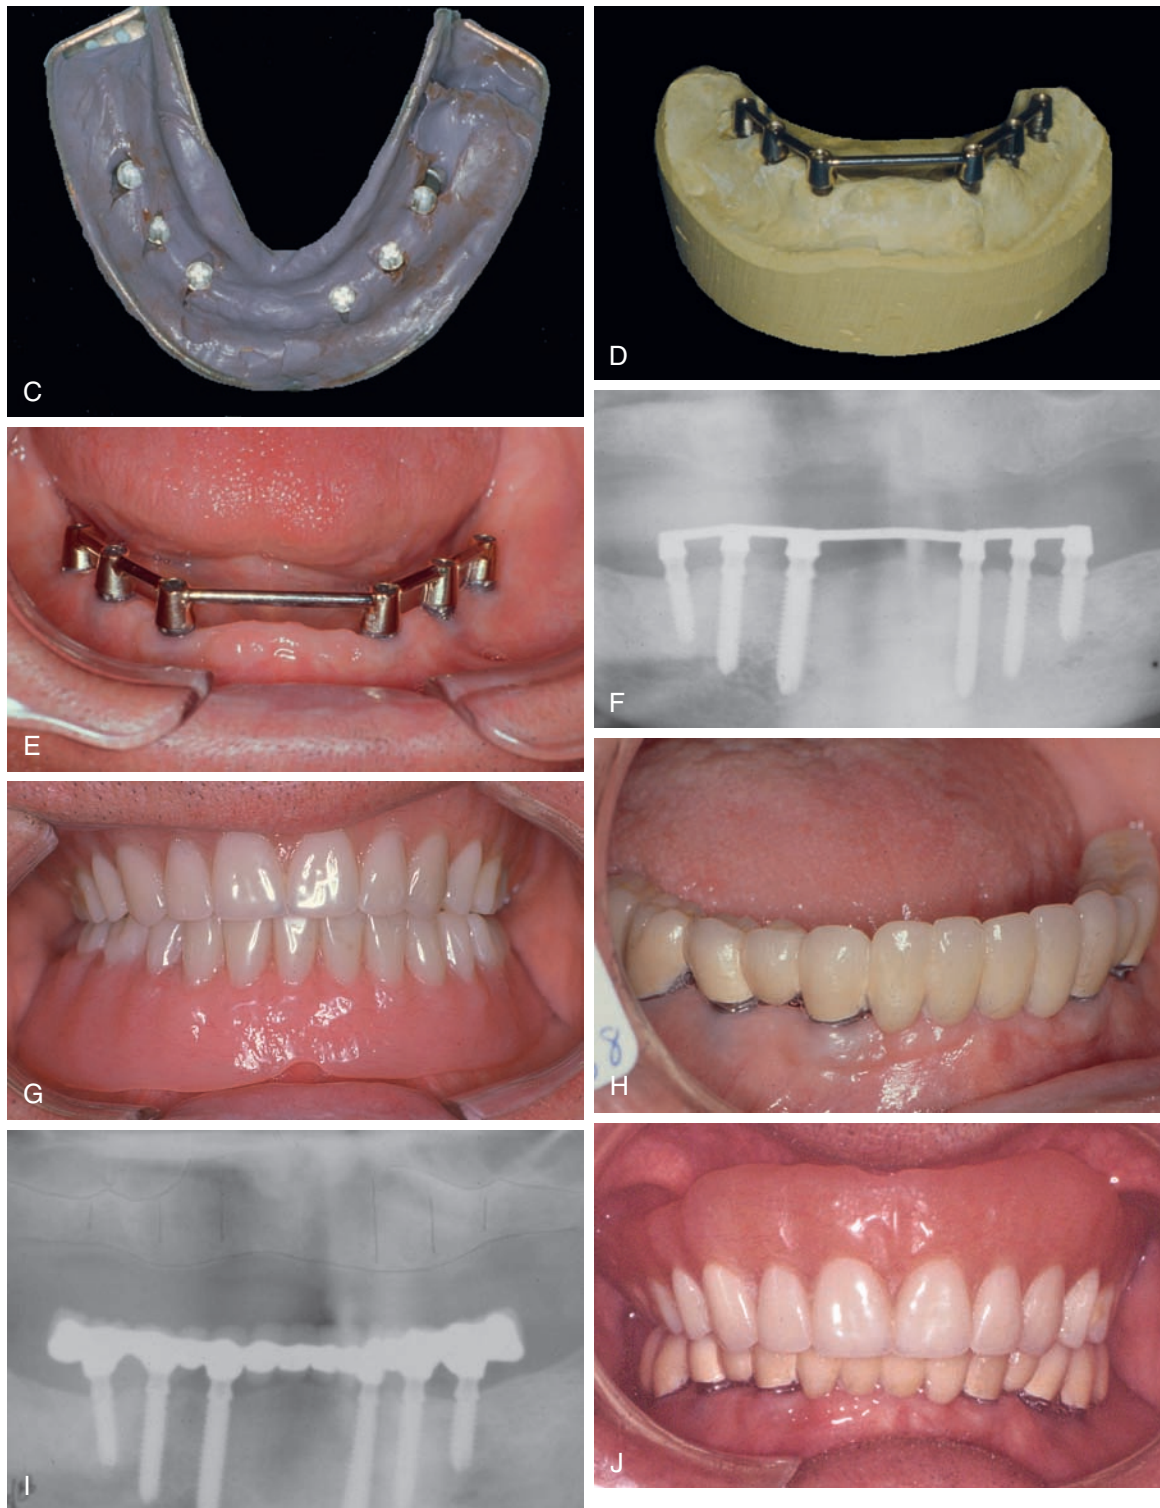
cont'd. C, Immediate impression taken with impression coping for laboratory model and analogs. D, Bar fabricated for placement within 24 hours. E, Bar placement passively seated and rigidly connecting all implants. F, Panoramic view of integrated implants with passively connecting bar. G, Full maxillary denture and mandibular over-denture. H, Conversion of bar to fixed mandibular prosthesis. I, Panoramic radiograph 2 years after implant placement and insertion of fixed bridge. J, Ten-year postoperative clinical photo.
